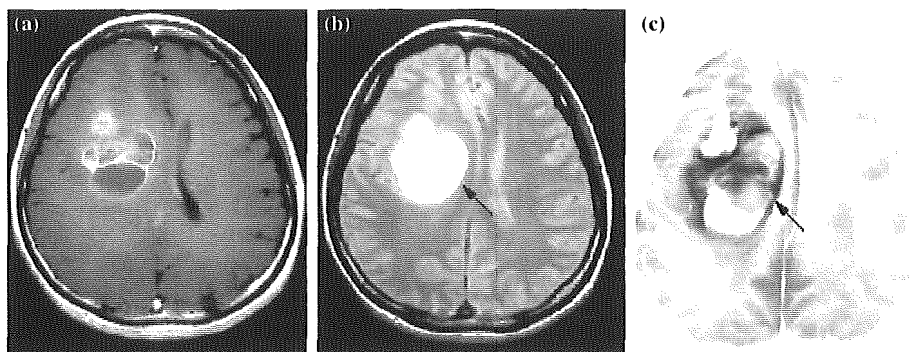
MR images and 3DAC in Case 18. (A) Gd-T1WI shows a huge glioblastoma in the right frontal lobe. Neither PDWI (B) nor 3DAC (C) reveal the corona radiata, due to the presence of a huge tumor. Whether the corona radiata was not apparent due to heavy compression or invasion of tumor bulk was unclear.
